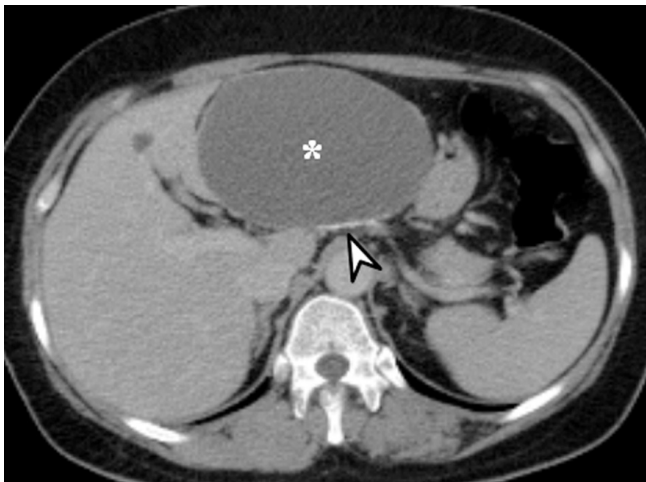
Mucinous cystic neoplasm of liver in 56-year-old female. Large, well-defined, unilocular cystic mass (asterisk) is located in left lateral section of liver as shown on axial contrast-enhanced CT image. Peripheral curvilinear calcification (arrowhead) is noted, and there is no enhancing solid component. Hepatic segmentectomy was performed, and lesion was confirmed as being mucinous cystic neoplasm (biliary cystadenoma) with dystrophic calcification and containing internal hemorrhage.
